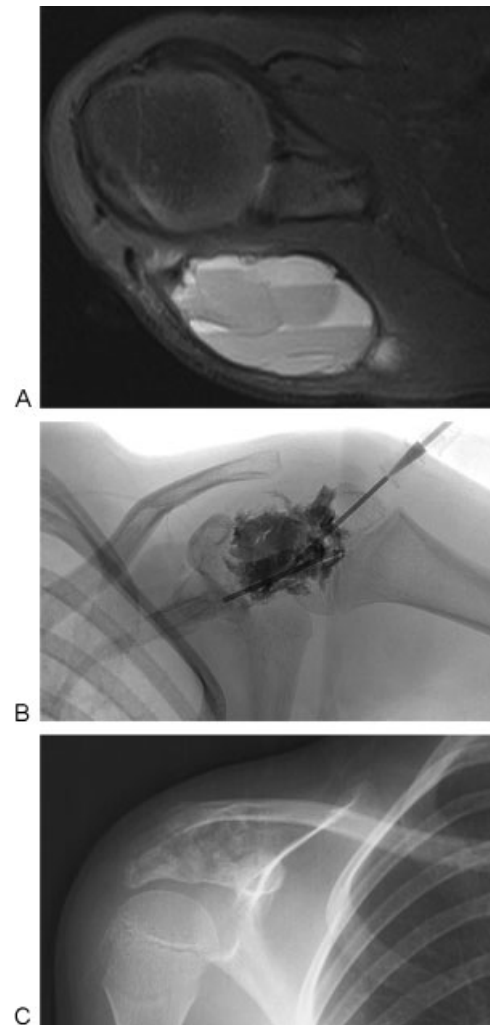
A 7-year-old patient with enlarging painful posterior right shoulder mass. (A) Axial MRI with multiple fluid-fluid levels and cortical thinning. On biopsy, this was proven to be an aneurysmal bone cyst (ABC). (B) The patient was placed prone under general anesthesia and bloody contents were aspirated from the ABC. Contrast injection showed absent vessel outflow and cyst communication. Foamed concentrated doxycycline was injected with double 18-gauge needles to allow the sclerosant to egress to prevent lesion overfilling. (C) Expected bony sclerosis posttreatment. MRI, magnetic resonance imaging.
